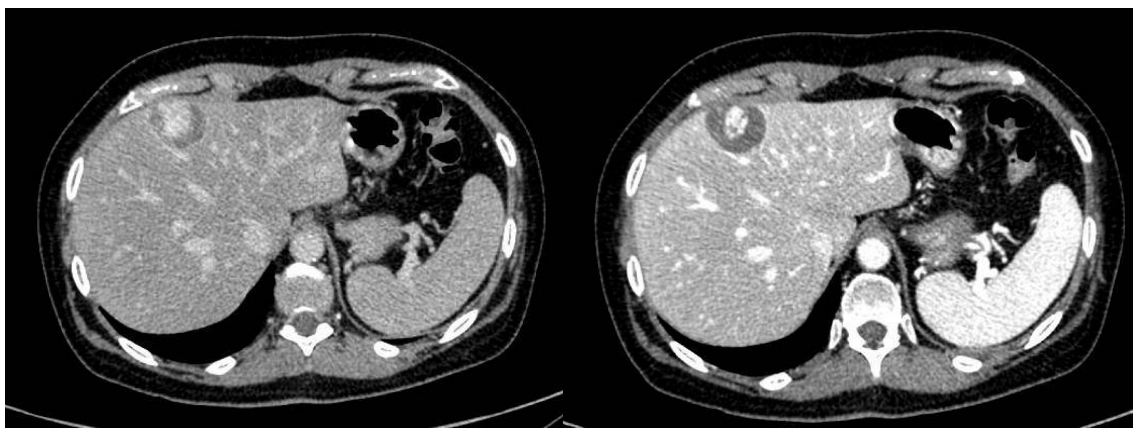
CT scan showing a liver lesion in segment IV, with central nodular enhancement that increases significantly in late phases after contrast administration.
